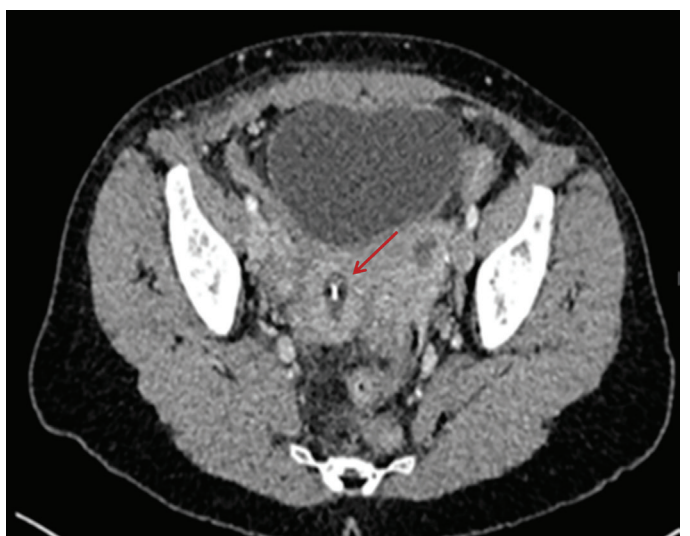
Axial computed tomography abdomen and pelvis showing an intrauterine device *in situ*.
